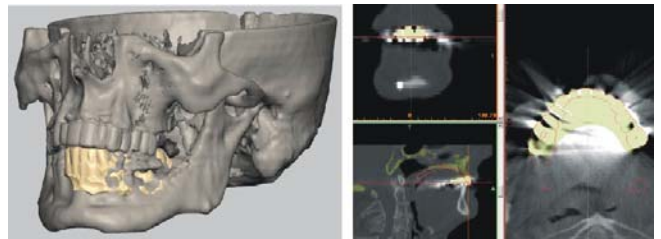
Teeth in occlusion aligned with mandible/maxilla (left) with accuracy verified with original CT data (right).
